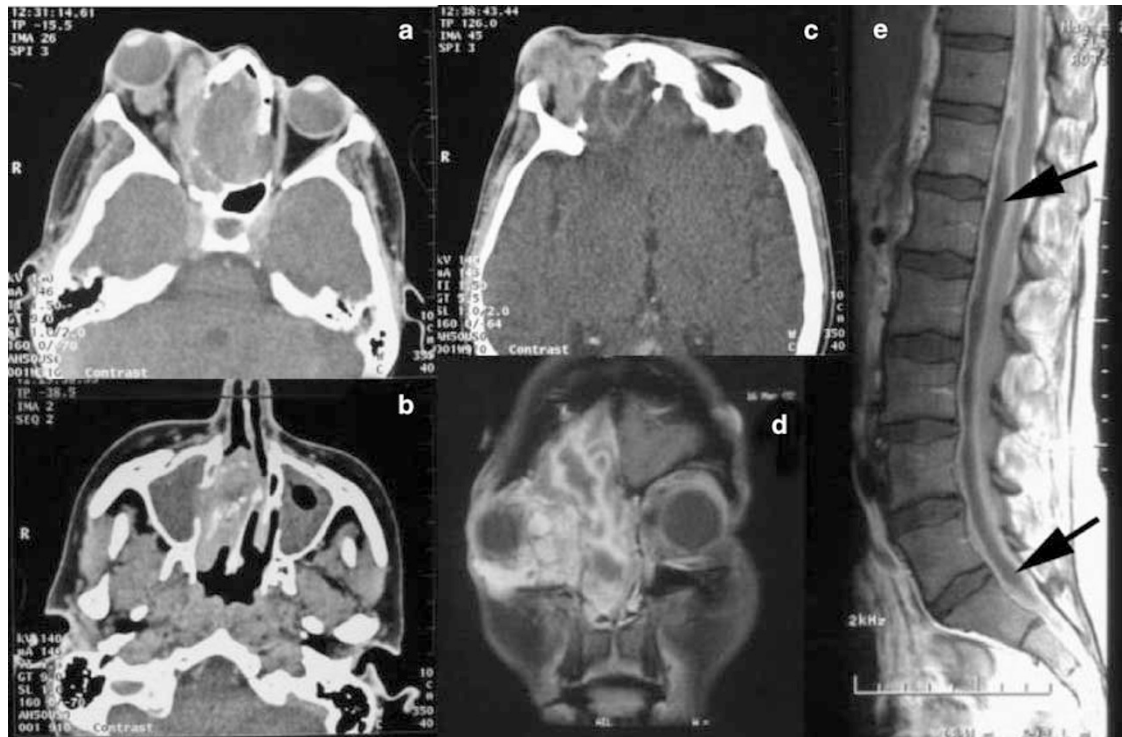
(a) CT scan demonstrating orbital varices and nasal encephalocele. (b) CT scan demonstrating encephalocele causing obstruction to maxillary antral drainage. (c) CT scan showing brain abscess in the right frontal lobe. (d) Coronal MRI scan through the orbits to show the encephalocele and extensive cerebritis/abscess formation. (e) Saggittal MRI of the spine showing an intraspinal subdural empyema (arrowheads).
